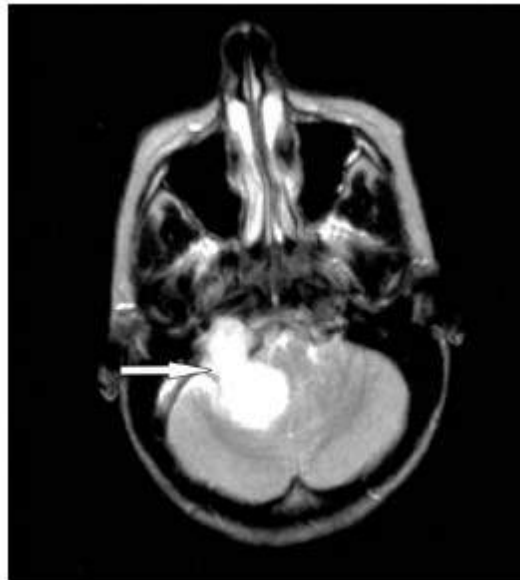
Axial T2-weighted MRI scan with gadolinium DTPA contrast demonstrating atypical enhancing dumbbell tumour occupying both middle and posterior fossae. There is significant brainstem compression.
